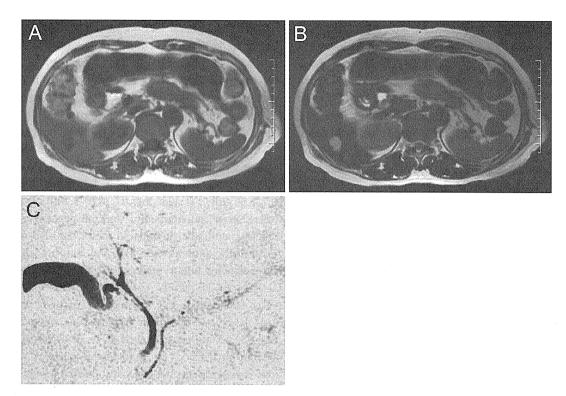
Magnetic resonance imaging (MRI) of the pancreas. MRI demonstrated swelling in the body and tail of the pancreas with no obvious intensity of change (A; T1 intensive image, B; T2 intensive image). Magnetic resonance cholangiopancreatography (MRCP) revealed obstruction of the main pancreatic duct in the body (C).
